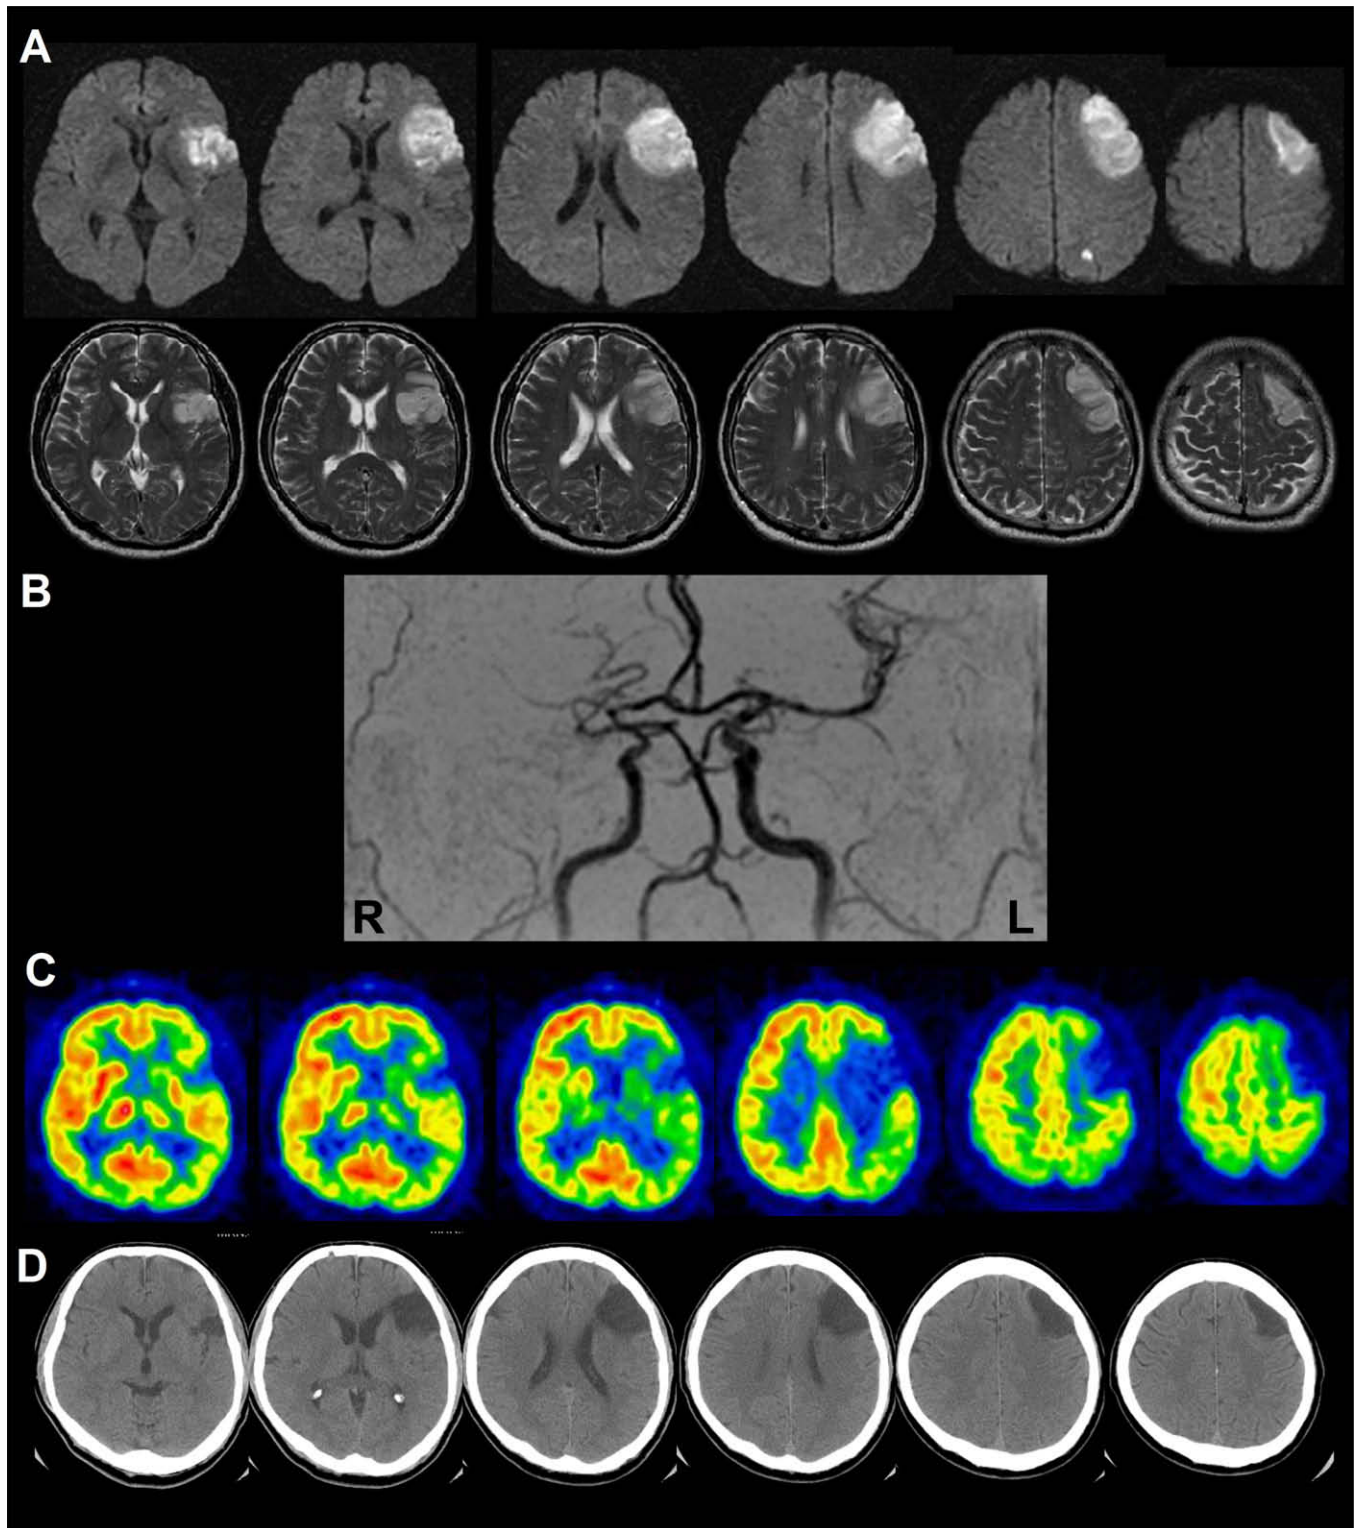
(A) Diffusion-weighted (upper row) and T2-weighted (lower row) axial MRIs performed on the first day of onset showing high signal intensity in the left middle frontal gyrus, the lower part of the left precentral gyrus, the left inferior frontal gyrus, left insula and a small lacune in the left superior parietal lobule. (B) Magnetic resonance angiography revealed occlusion of the right proximal middle cerebral artery (MCA) and the distal branch of the left MCA. (C) [18F]-Fluorodeoxyglucose positron emission tomography axial images taken 1 month after onset showing large metabolic defects in the left frontal area with mild hypometabolism in the left parietotemporal area. (D) Axial CT scans taken 4 months post-stroke showed chronic infarction in the left frontal area. L = left, R = right.
